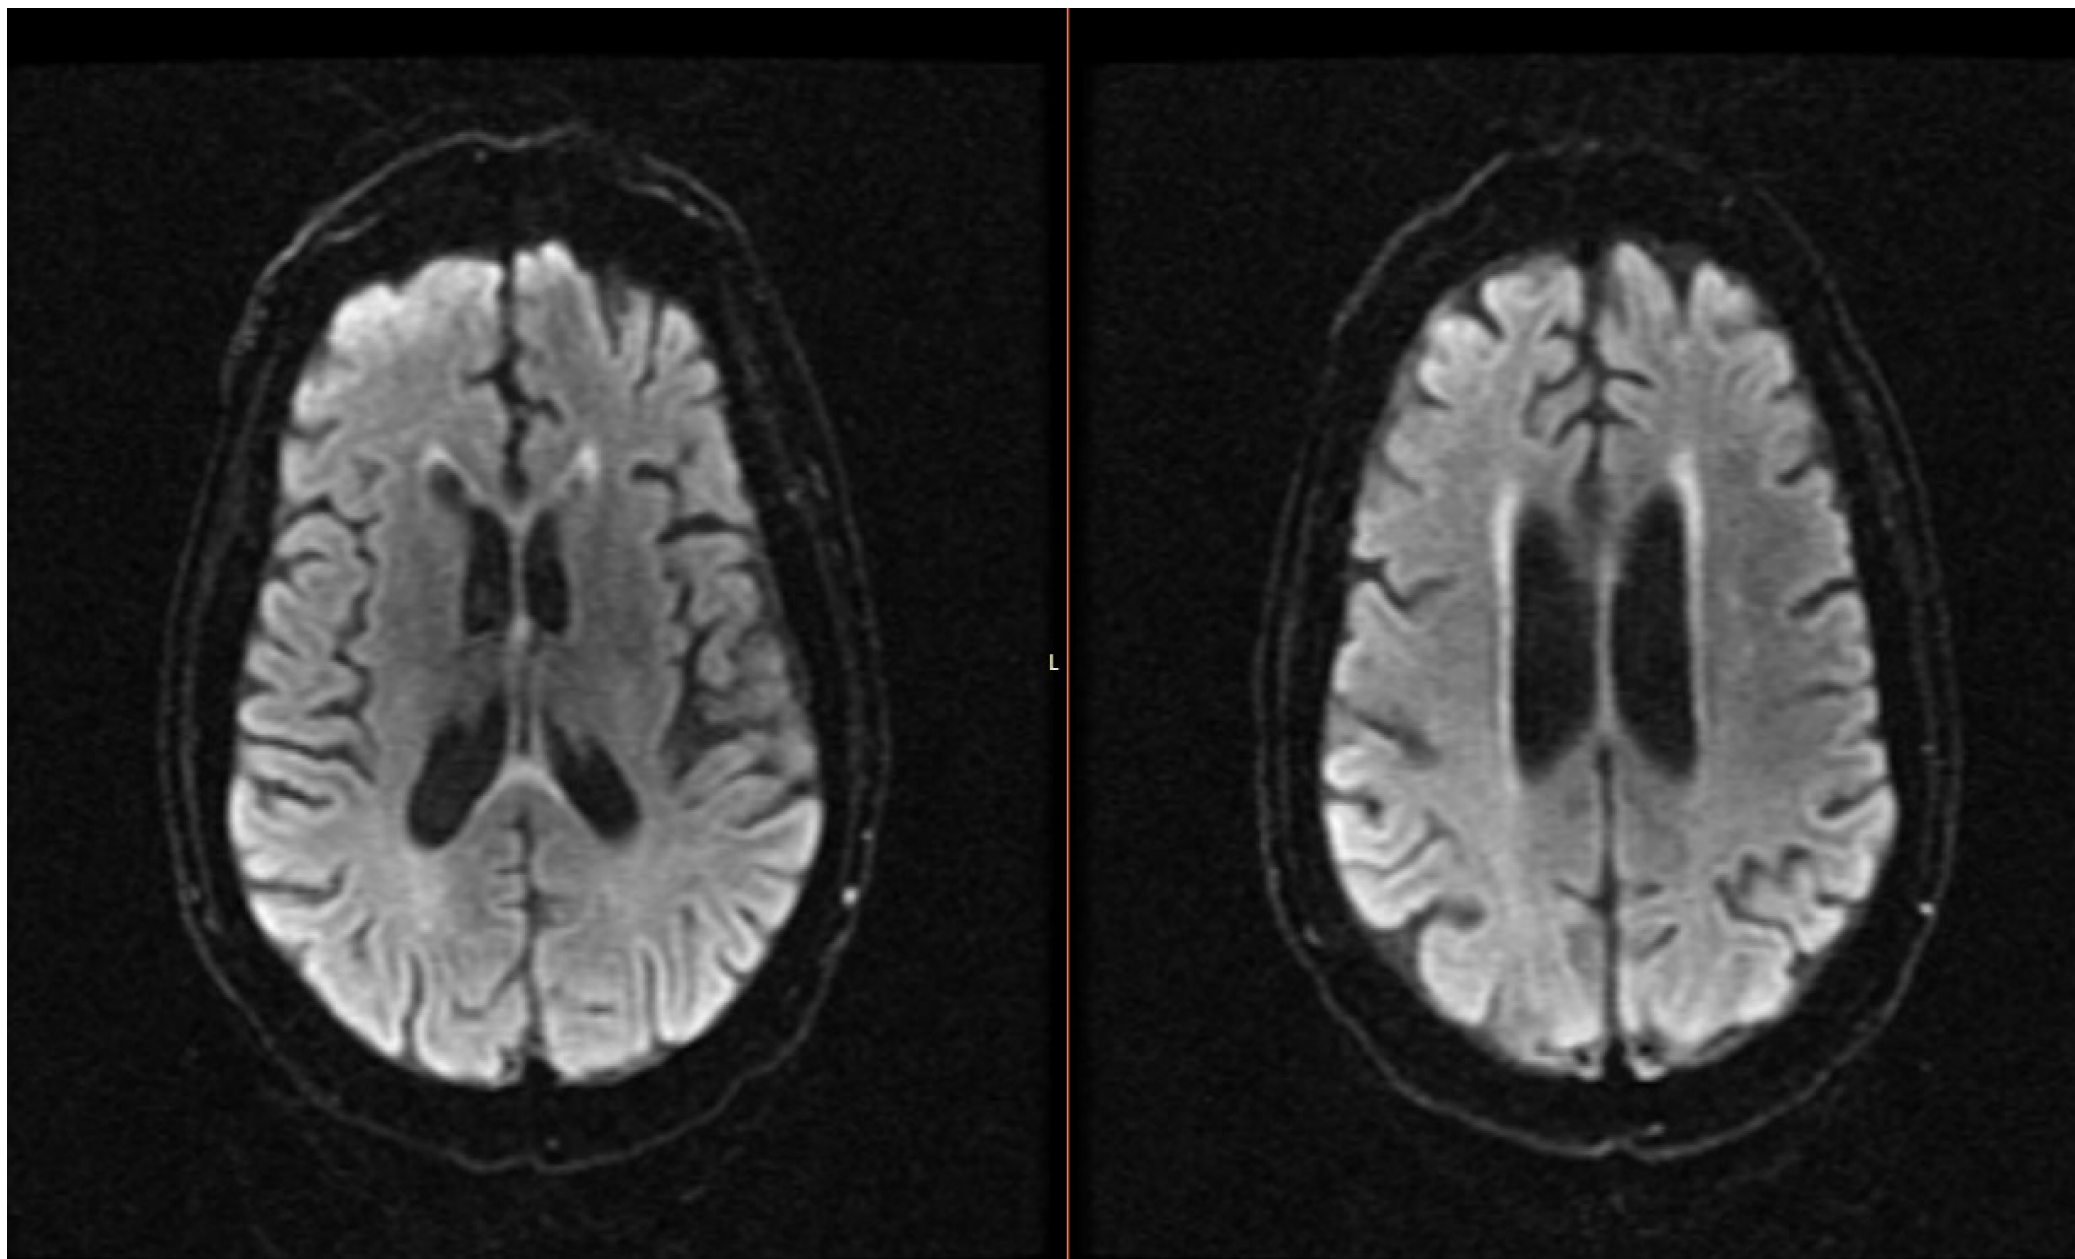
MRI revealed an increased FLAIR signal in the inferior corpus callosum and mild restricted diffusion in the corpus callosum’s genu and splenium
